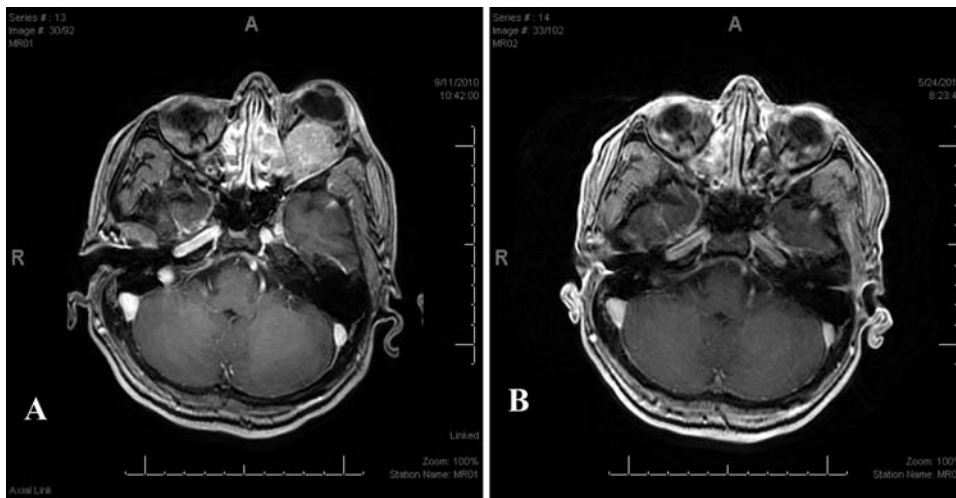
A, MRI scan showing a large soft tissue mass originating from the left maxillary sinus or left nasal cavity with extension and partial destruction of the orbital floor with elevation and distortion of the globe. B, MRI scan 4 months after completion of therapy.
